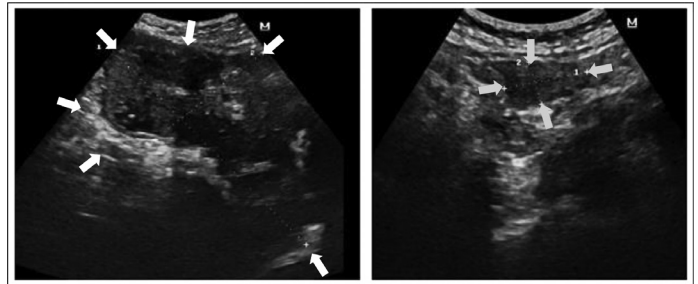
Transrectal ultrasound showing the (a) 16.2 x 9.4 x 7.8 cm lobulated heterogeneous solid abdominopelvic mass (yellow arrow), more to the left and (b) the 2.9 x 2.0 x 1.5 cm solid mass at the right adnexal area (blue arrow).
